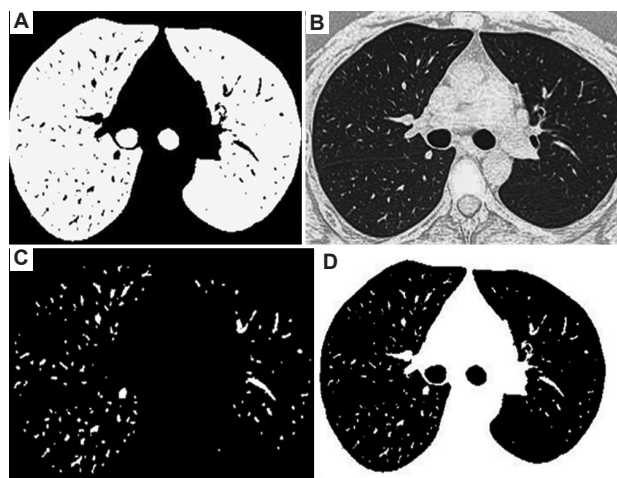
Experimental images of a normal lung CT slice. (A) Non-COVID-19 input CT slice. (B) Segmented image. (C) Extracted ROI. (D) Non-COVID-19 nodules. These images were generated using Python. Abbreviations: CT: Computed tomography; ROI: Region of interest.
